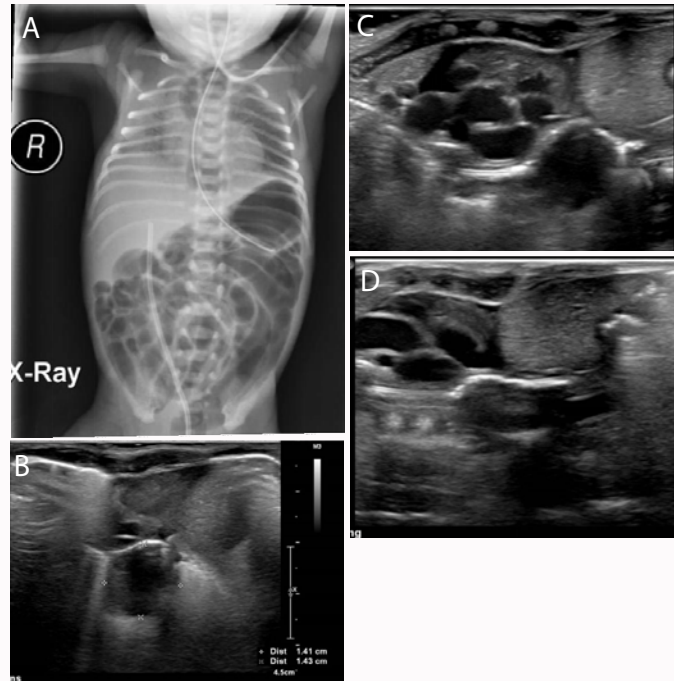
4a) The CXR shows radiolucency at sternal region. Case 11: 4b, 4c, and 4d depict the ultrasound study that was performed on day 4 to further evaluate the cause of the lucency. In the posterior lower chest, there was a well-margined cystic structure measuring 15 mm (craniocaudal) × 14 mm (transverse) × 12.5 mm (anteroposterior) dimension, and which was near the midline.
